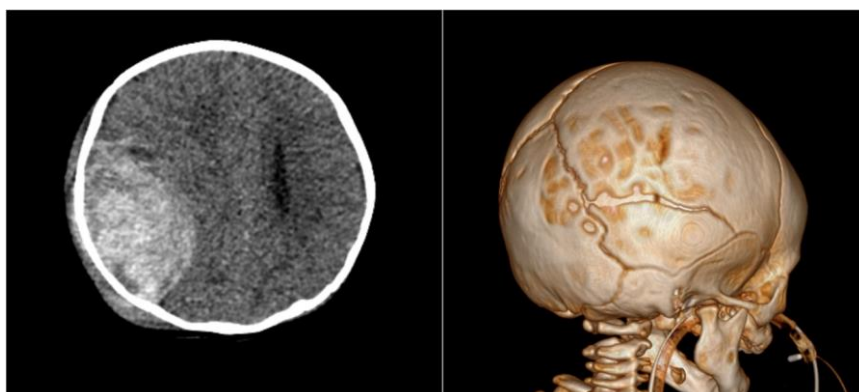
CT scan of a 5-month-old male infant showing a parietal skull fracture associated with epidural hematoma following an accidental fall from an infant carrier. The patient underwent surgical evacuation of the epidural hematoma and required intensive care admission.
